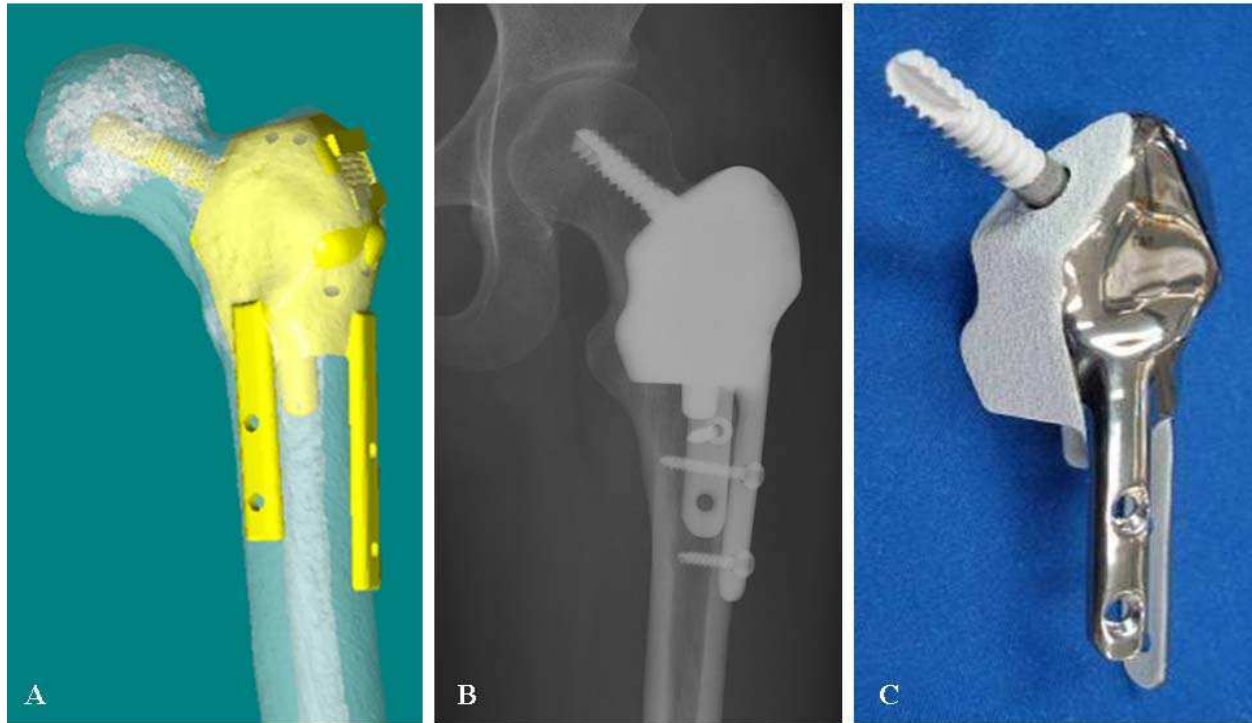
(A) A joint-saving, CAD custom prosthesis in Patient 14 with low grade chondrosarcoma of left proximal femur is shown. (B) An antero-posterior view of plain radiograph of hip at postoperative one year is shown. The computer navigation technique allowed precise surgical planning, tumor resection and an accurate fit of a CAD custom prosthesis. (C) A specially designed custom prosthesis is shown. Additional extracortical plates and screw at femoral head offered excellent fixation and stability for the reconstruction. Hydroxyapatite that could facilitate osseointegration was coated at the surface of all bone-implant junctions of the prosthesis
